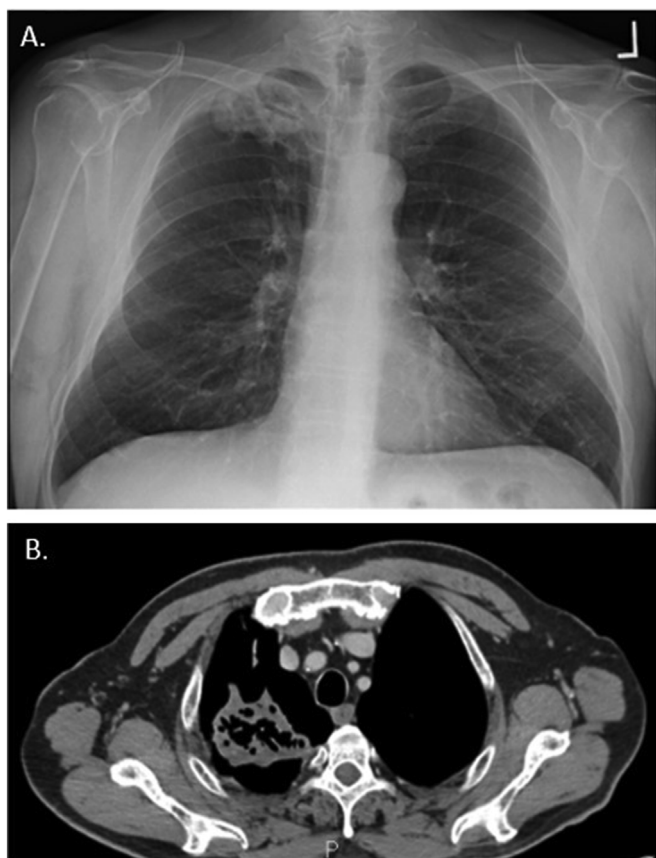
A. Chest X-ray showing a rounded mass in right upper lobe B. Chest CT scan showing a loculated mass with thickened border and central cavity zones.
